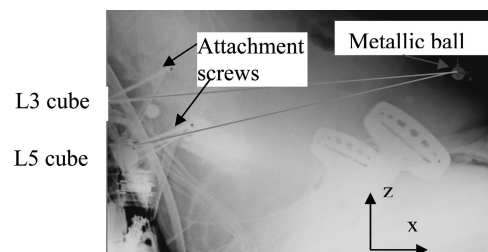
X-ray images of the PMHS (477) in the seat (pretest configuration).
